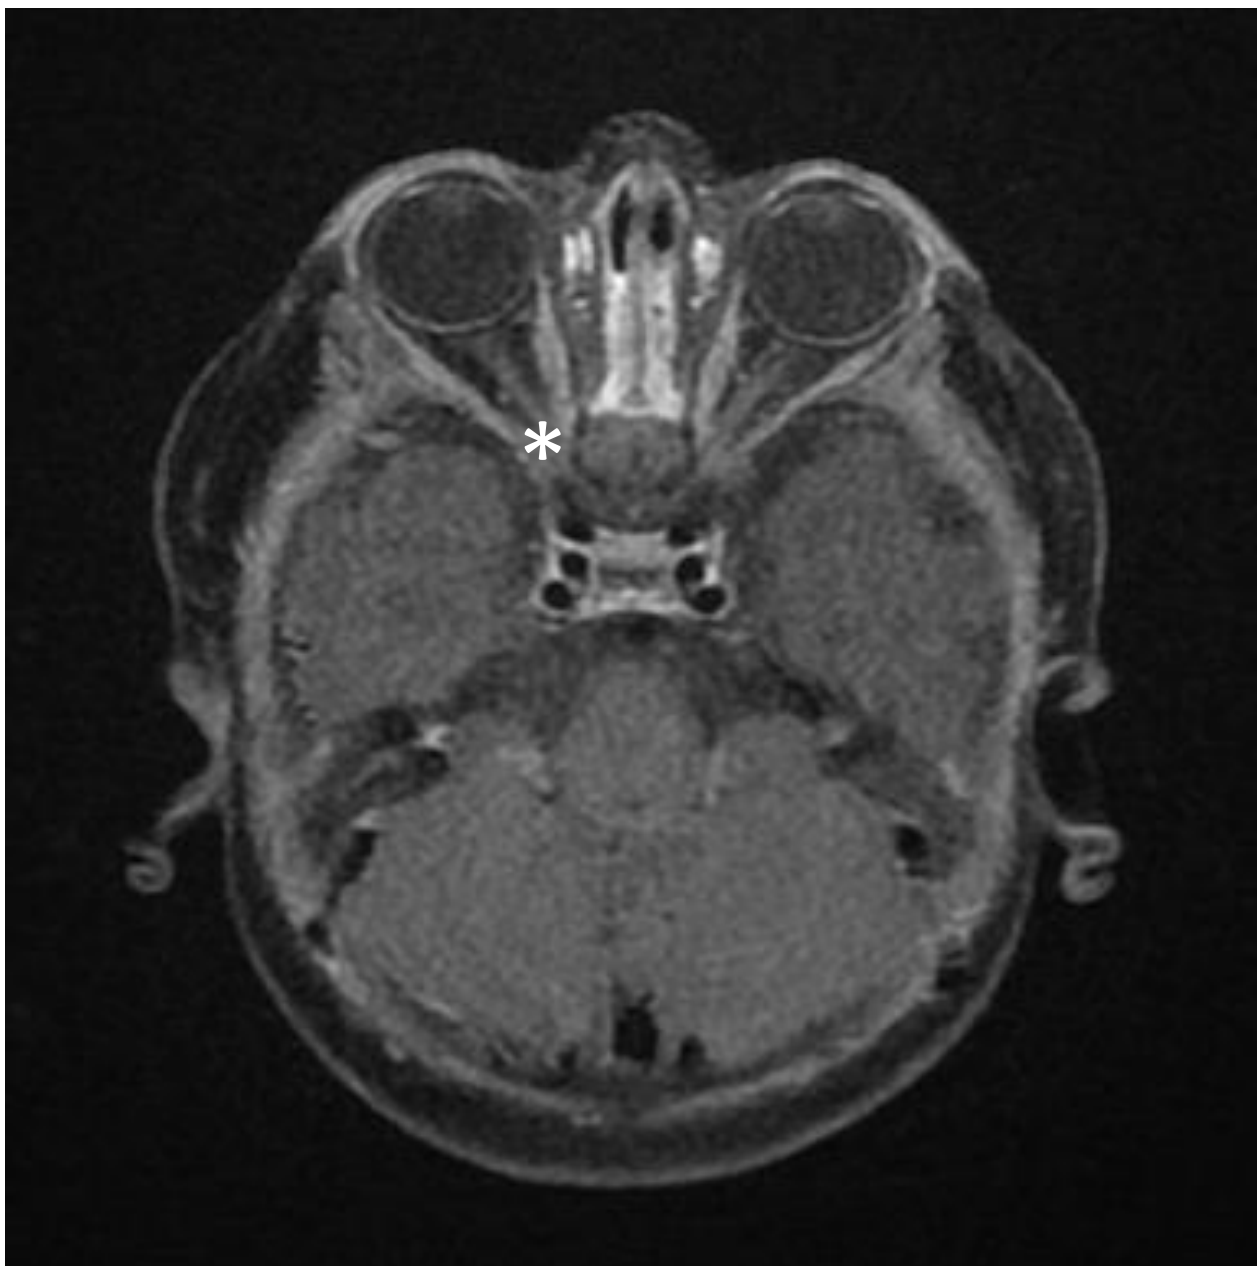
MRI Axial T1-Weighted: Narrowed Optic Canals
